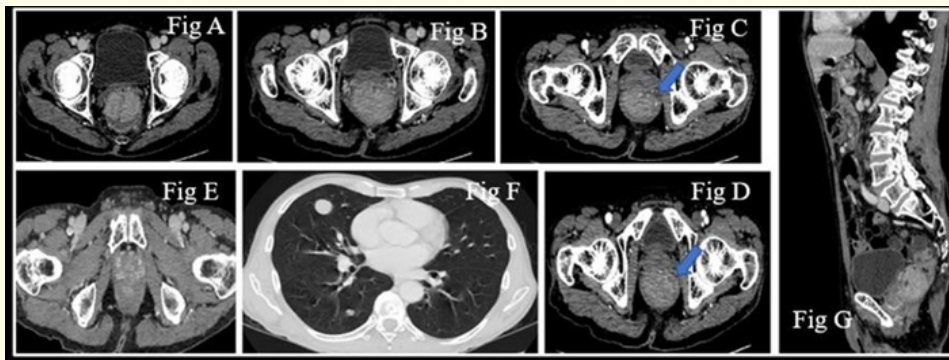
CT images of HPE proven Adenocarcinoma – Well differentiated. A, G: shows a heterogeneously enhancing endophytic lesion of the rectum. B: shows the thickening of mesorectal fascia. C and D show tuft of vessels in the lateral aspect of the lesion in the arterial phase. E: Shows the extension of the lesion into the anal canal. F: Lung metastases.
